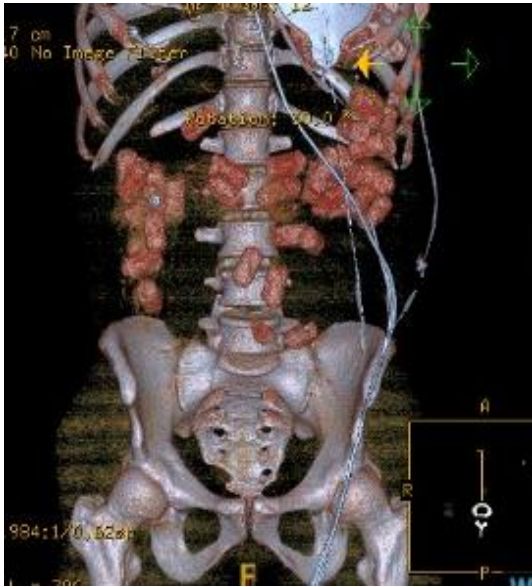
Three-dimensional reconstruction images of the drug packets visualized on a CT scan of the abdomen and pelvis.
